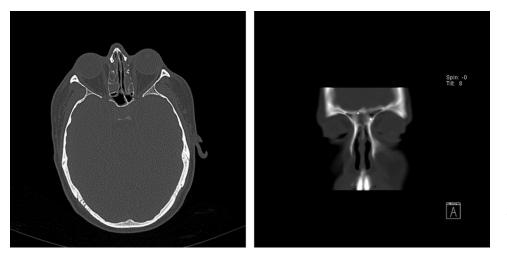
Axial and coronal CT scans showing radio-opaque objects in frontal and ethmoid recesses bilaterally.
